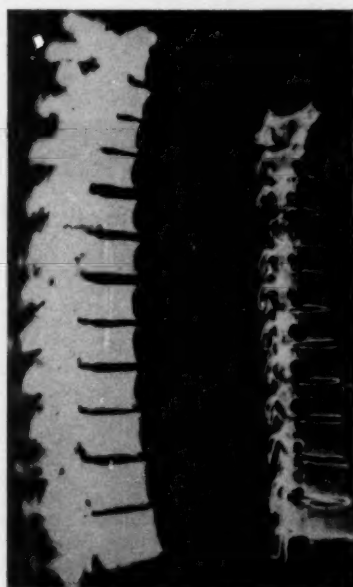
Radiograph of the spine from a case of fluorosis compared with normal
